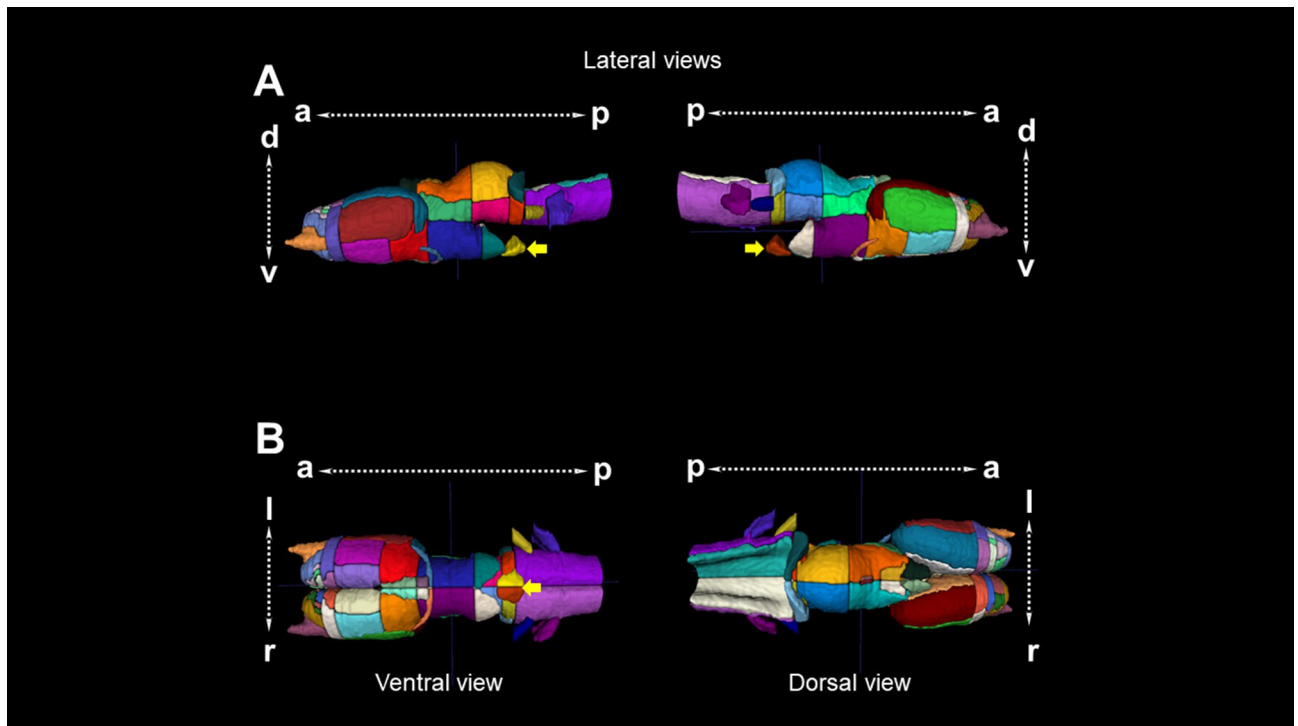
3D reconstruction of the brain of *Ambystoma mexicanum* employing MRI. (A) Lateral views from the left and right sides of the complete 3D reconstruction created from our template. (B) Ventral (left) and dorsal (right) views of the complete 3D reconstruction. Every reconstruction shows each region in a different color when manual delineation was possible. Yellow arrows denote the pituitary gland.
